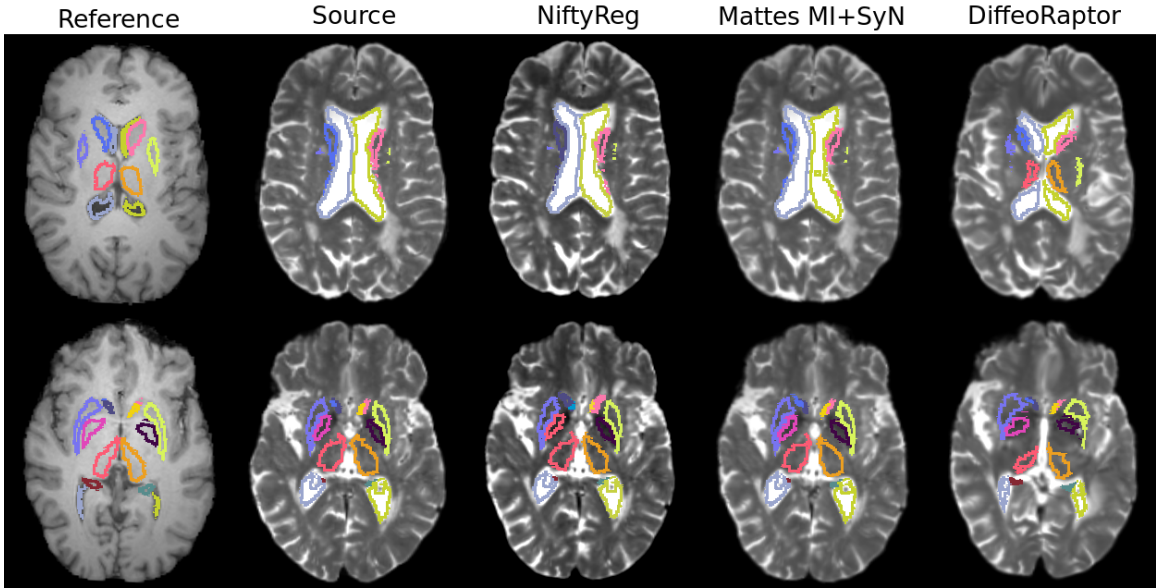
From the left to right: axial slices of the T1w reference volume from the IXI dataset, the T2w MRI source volume of the OASIS3 dataset, result of NiftyReg, Mattes MI+SyN, and DiffeoRaptor respectively. Rows show different axial views. Subcortical segmentations are shown in colored contours.
